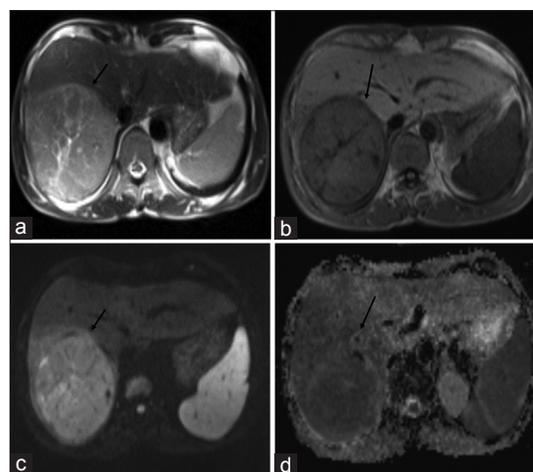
Magnetic resonance imaging of the same patient as Figure 3. Axial T2-weighted image showing large hyperintense lesion (black arrow, a) in the right lobe and appearing heterogeneously hyperintense on axial T1-weighted image (black arrow, b). The lesion is showing diffusion restriction appearing hyperintense the axial diffusion-weighted imaging series (black arrow, c) and appearing hypointense on the apparent diffusion coefficient mapping – (black arrow, d) mean apparent diffusion coefficient value is $0.9 \times 10^{-3} \text{ mm}^2/\text{s}$. Diagnosis is confirmed as hepatocellular carcinoma by biopsy
